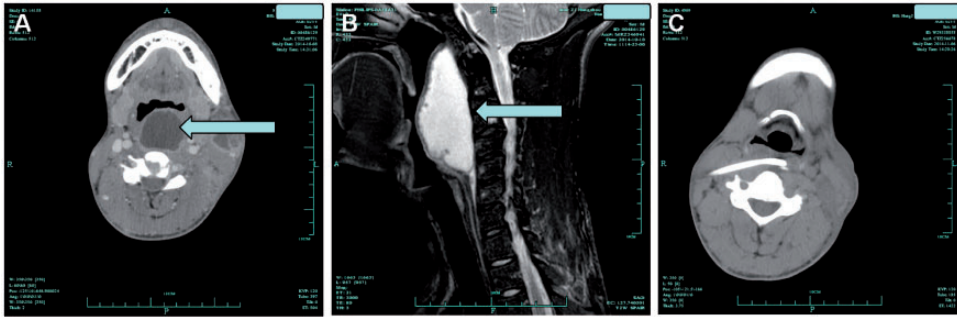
a, Neck enhanced CT shows an abscess in the retropharynx (arrows). b, MRI shows a scan of the cervical spine indicating abnormal signals in the left cervical soft tissues (with arrow). c, Neck-enhanced CT shows that the RPA is not visible
